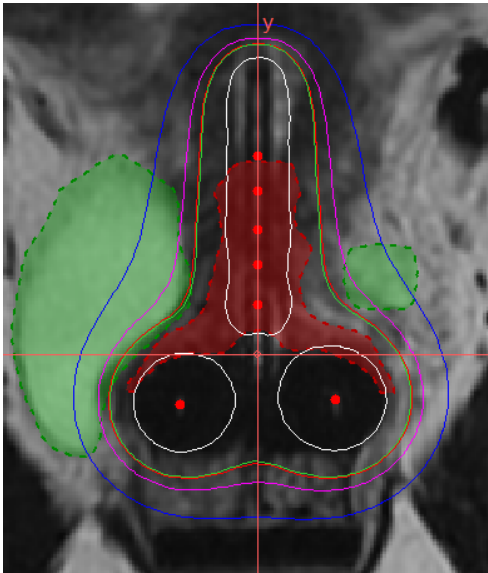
Typical pear-shaped dose distribution projected on 2D sagittal delineated MRI for a patient. Contours for the High-Risk Clinical Target Volume (HR-CTV) and bladder are shown in red and green respectively. Isodose lines extend beyond the HR-CTV to form the typical pear shape.
